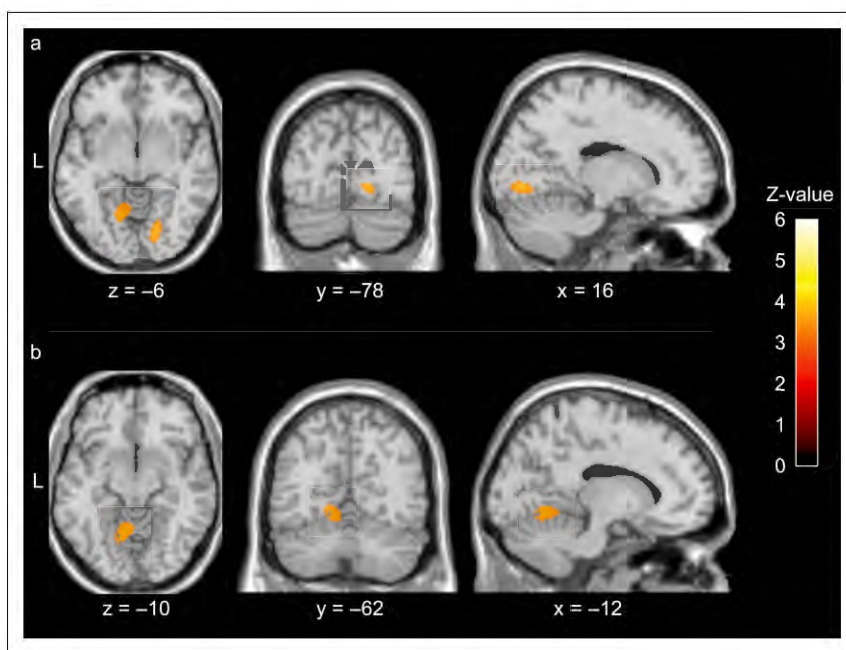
When comparing the brain metabolism of patients with “visual snow” to healthy controls in [^{18}F]-FDG PET using a paired t -test in SPM8, the right lingual gyrus (in [a]; Montreal Neurological Institute 16-78-5; $k_E = 101$; $Z_E = 3.41$; $P < .001$) and the anterior lobe of the left cerebellum (in [b]; Montreal Neurological Institute -12-62-9; $k_E = 152$; $Z_E = 3.28$, $P = .001$) were metabolically more active in patients with “visual snow.” The figure was thresholded at $P \leq .001$.
